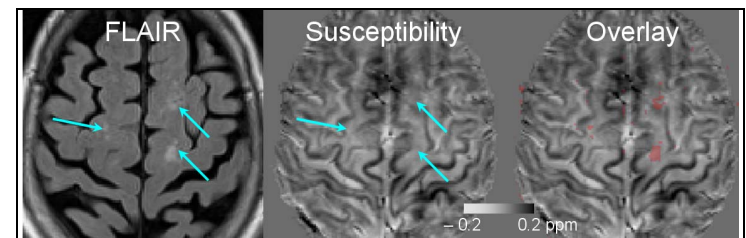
Comparison of FLAIR and susceptibility maps of an asymptomatic subject. Hyperintense spots are seen in the FLAIR images while susceptibility maps reveal normal myelination in the same locations consistent with asymptomatic clinical presentation.
